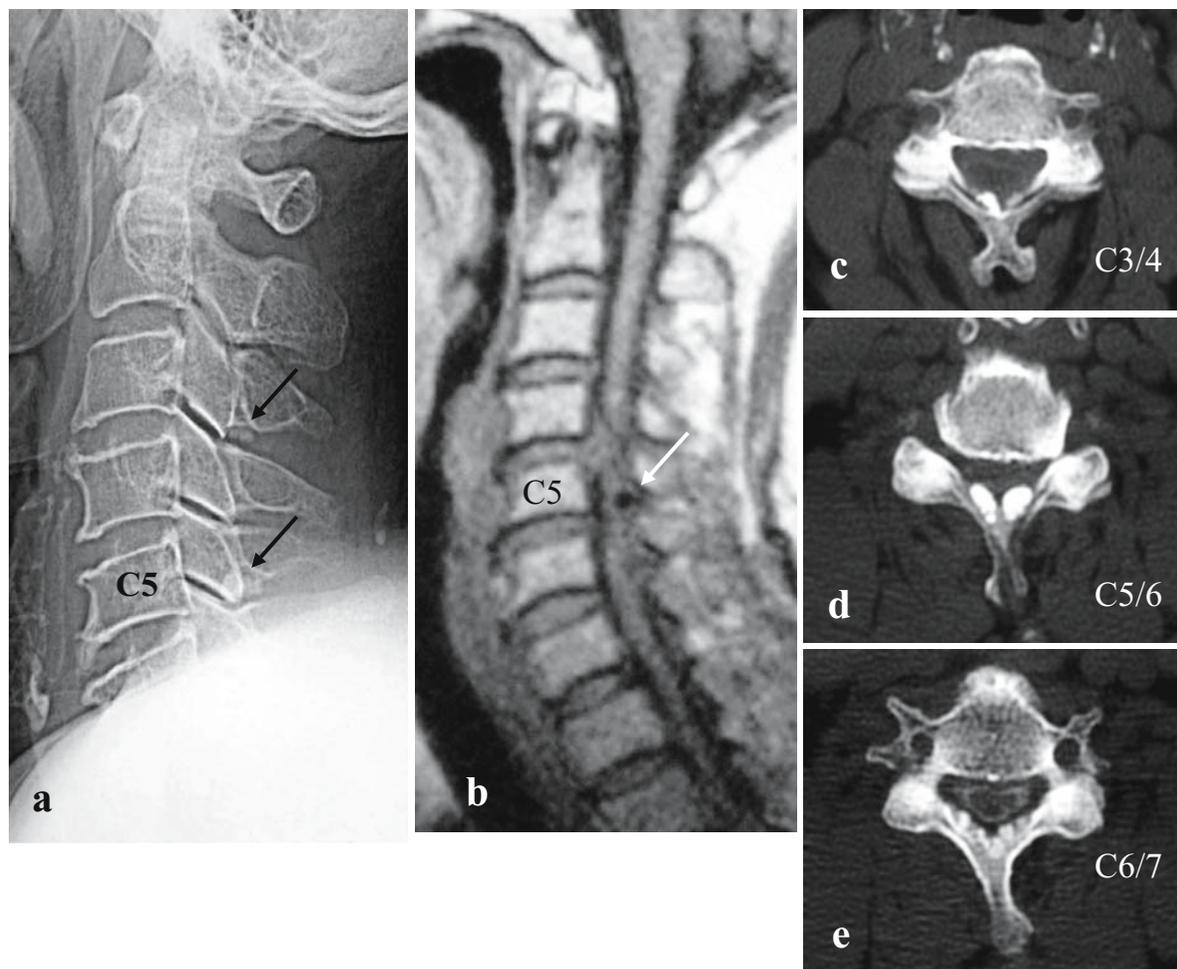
Calcification in the ligamentum flavum in a 74-year-old woman. a Lateral radiograph shows oval nodular masses in the posterior spinal canal at the C3-C4 and C5-C6 levels (arrows). b Sagittal T1-weighted MRI shows a round area of very low signal intensity at the corresponding location that indents the posterior aspect of the spinal cord at the C5-C6
